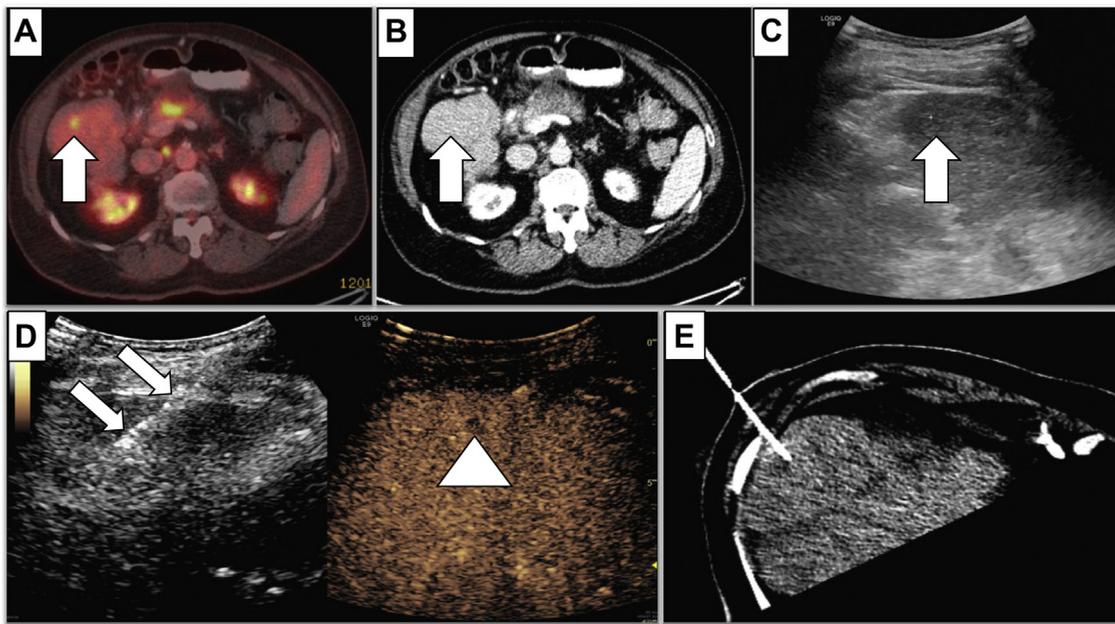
Percutaneous liver biopsy for a 76-year-old woman with a prior history of metastatic pancreatic cancer (FDG-avid lesion shown in A, arrow). The liver lesion was small in size and difficult to visualize on CT (B, arrow) or B-mode US (C, arrow). A single dose of US contrast (Lumason®, Bracco Imaging) improved visualization due to the discrepancy in vascularity between the lesion and the surrounding normal liver parenchyma (D, arrowhead), which allowed successful real-time needle biopsy (D, arrows). The needle location was further confirmed with noncontrast CT (E). Ultrasound-guided biopsy of the nodule confirmed results consistent with metastasis from the patient's known pancreatic primary. CT, computed tomography; US, ultrasound.
